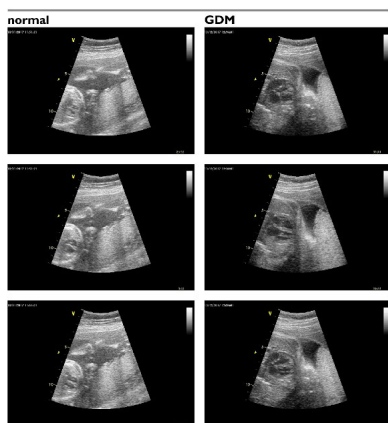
Ultrasound images of fetal hearts from normal and diabetic mother.
